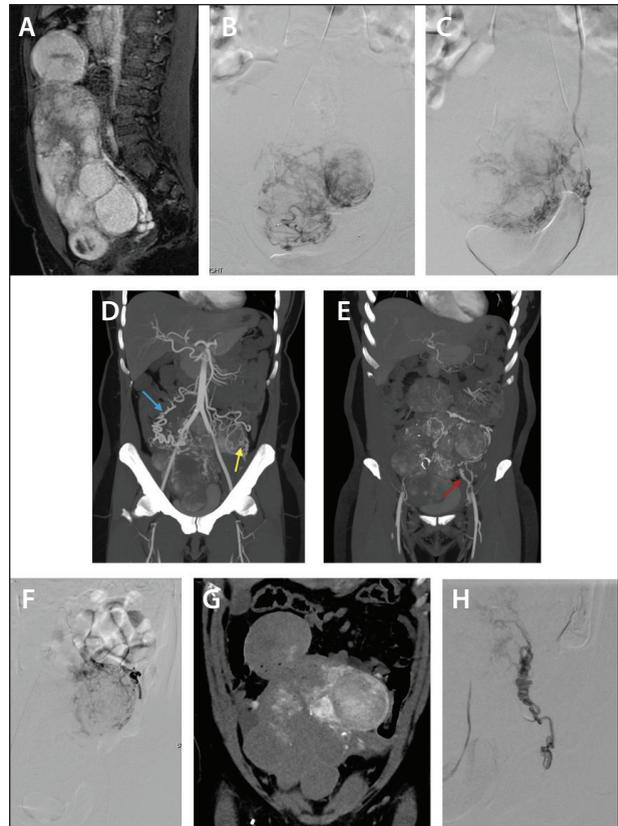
A woman in her early 40s with preprocedure sagittal T1 MRI demonstrating enhancement of multiple uterine fibroids (A). Digital subtraction angiography (DSA) showed catheterization of the right uterine artery (B) and left uterine artery, with filling of inferior fibroids but not the complete uterus (C). CTA demonstrated collateral blood supply from right ovarian artery (D, blue arrow) and branch of inferior mesenteric artery (IMA; yellow arrow) and left round ligament artery (E, red arrow) to the fibroids. DSA showed selective catheterization of a branch of the IMA (F) and intraprocedural CTA confirmed filling of the fibroid without filling of the bowel (G). DSA showed selective catheterization of the left round ligament artery with filling of the fibroid (H). In total, the bilateral uterine arteries, right ovarian artery, a branch of the IMA, and a left round ligament artery were embolized.
